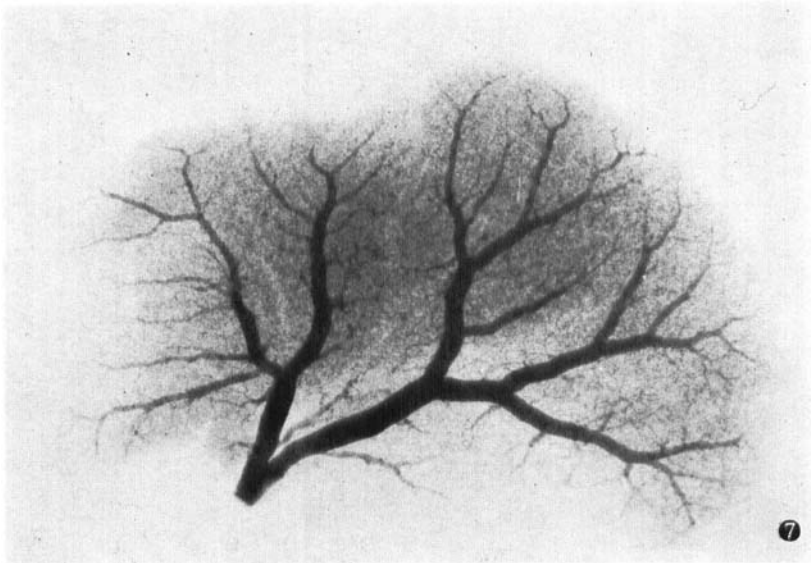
Radiograph of intrahepatic portal venous tree of cirrhotic liver. The course of vasculature was somewhat irregular, but neither marked stenosis nor distortion was seen.
